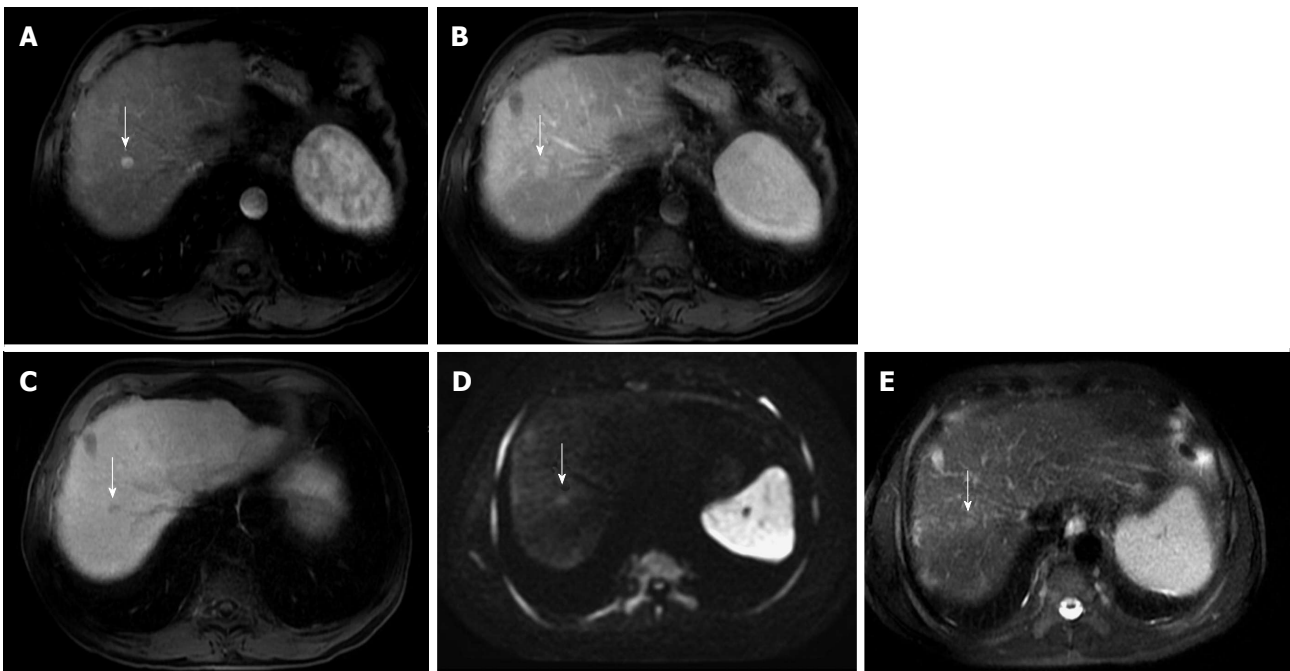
Small hepatocellular carcinoma showing the value of diffusion weighted image and hepatocyte-specific agents. A: Post-contrast fat-suppressed 3D-GRE T1-weighted images during the (A) late hepatic arterial, (B) delayed, and (C) hepatobiliary phases; D: Diffusion weighted image (DWI) ($b = 50$); E: Fat-suppressed SSFSE T2-weighted image. There is a small right hepatic lobe nodule, which demonstrates increased arterial enhancement (arrow, A), fading out on the delayed images (arrow, B), and demonstrates significantly decreased uptake on the hepatobiliary phase (arrow, C). The lesion also demonstrates clear increased signal on DWI (arrow, D) and subtle increased T2 signal (arrow, E). The constellation of findings is consistent with HCC. The decreased uptake on the hepatobiliary phase and increased signal on DWI increased the accuracy of HCC diagnosis in this patient with a small hypervascular nodule. HCC: Hepatocellular carcinoma; GRE: Gradient recalled echo; SSFSE: Single-shot fast spin-echo.
